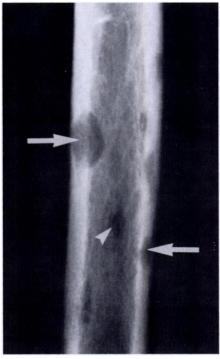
Angiosarcoma. Lateral radiograph of the femoral midshaft. Multiple lytic lesions are present; some appear to be cortically based (arrows), and others appear to originate in the medullary cavity (arrowhead). Confirmation of the location of any given lesion necessitates a second, perpendicular projection or cross-sectional imaging.
